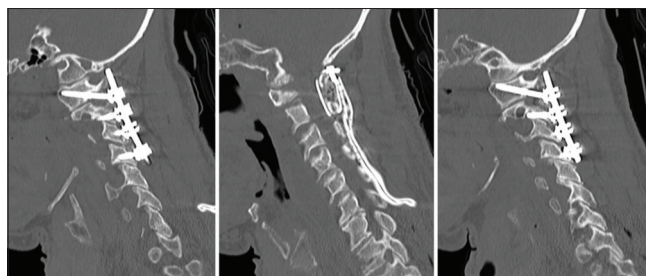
Sagittal computed tomography images of the cervical spine demonstrating subsequent removal of the odontoid screw with C1-4 posterior cervical instrumented fusion.
